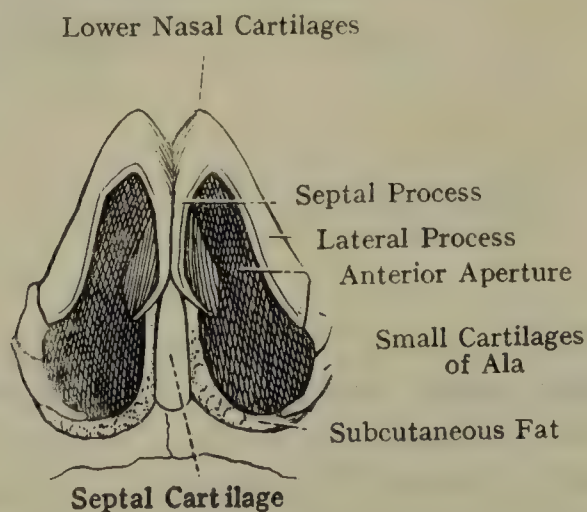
THE CARTILAGES OF THE NOSE (INFERIOR ASPECT) (ARNOLD).
